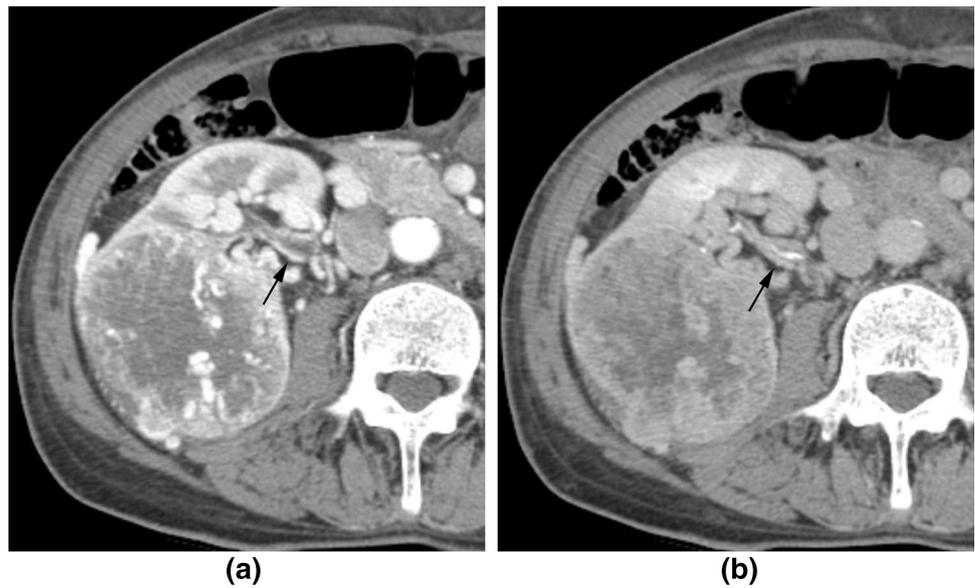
80-year-old male with clear cell carcinoma of left kidney (case 15). a Contrast-enhanced CT shows well-enhanced irregular wall thickening at the renal pelvis to the upper ureter at the corti-comedullary phase (arrow). b The thickened wall is isodense at the excretory phase without hydronephrosis (arrow)
